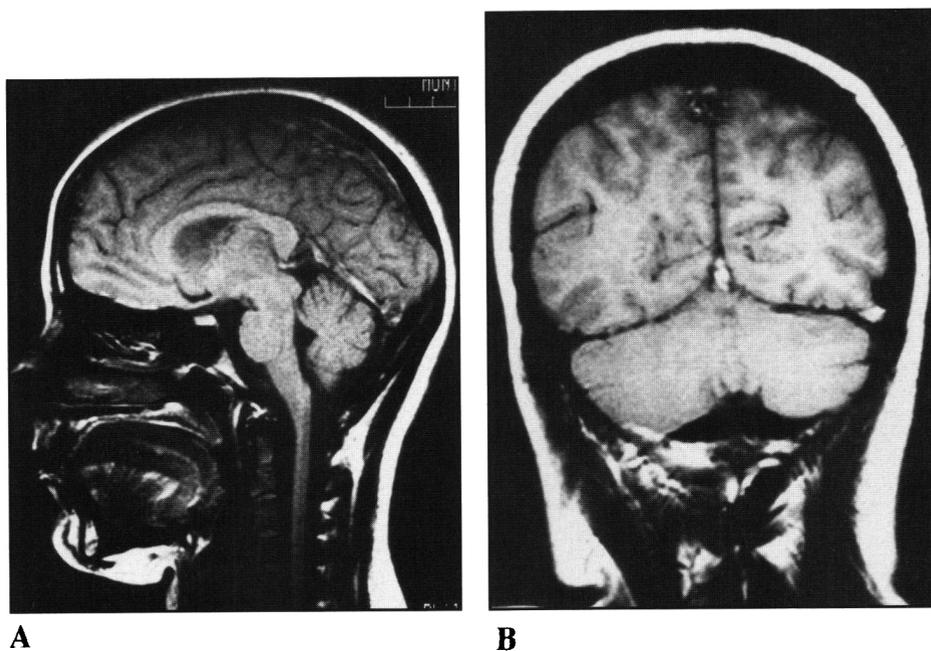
(A and B) — Patient 1 — T1-weighted SE MR (TR = 550ms, TE = 30ms) three days after admission. Hyperintensity in straight sinus, posterior sagittal sinus, left transverse and sigmoid sinuses and posterior left internal cerebral vein. Normal flow-void seen in right internal cerebral vein and vein of Galen.
